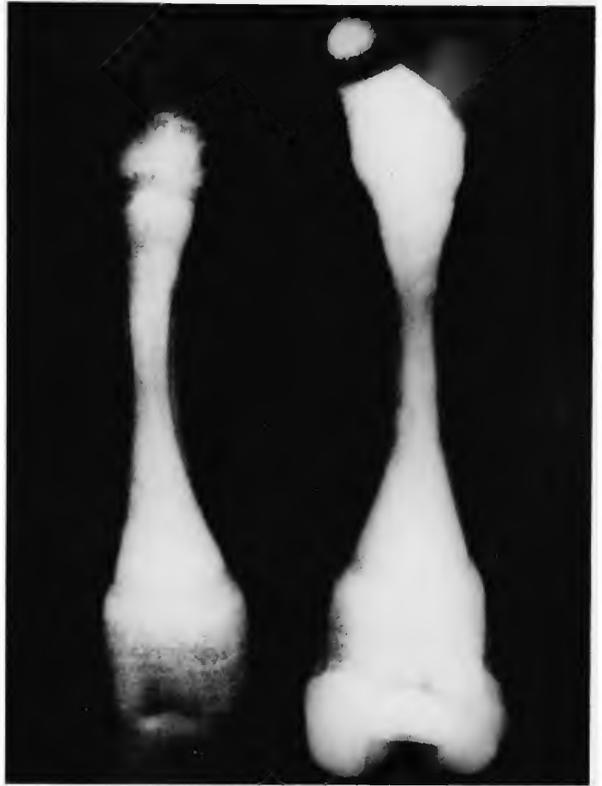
Osteopetrosis. X-ray of femur. Notice the great density of the secondary ossification centers and the alternating bands of density and lucency in the unremodeled metaphyses. (15-month-old male, MGH autopsy 34143.)
